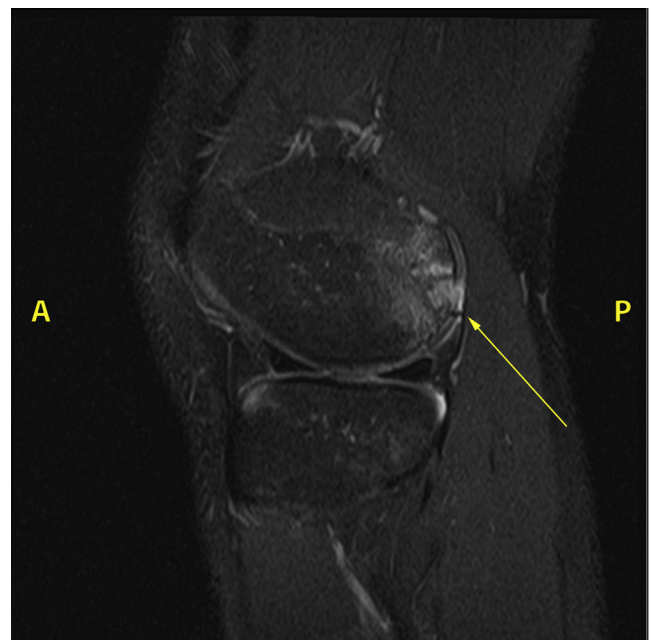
Sagittal view of a proton density fat suppressed magnetic resonance image of the left knee. The large osteochondral defect with a cystic component is visible on the posterior aspect of the lateral femoral condyle (yellow arrow). This location is difficult to access, making a posterior approach the preferred method of accessing this lesion. A, anterior; B, posterior.
